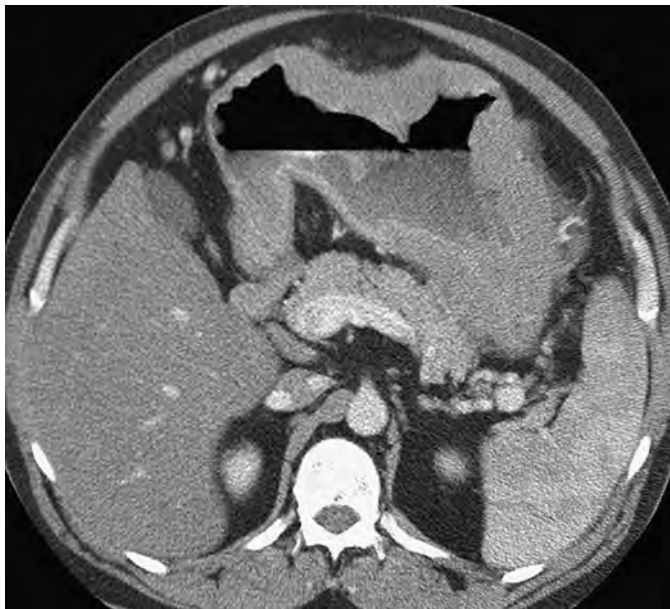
Gastric lymphoma on CT. CT scan shows marked thickening of the gastric wall with homogeneous enhancement caused by the infiltrative form of gastric lymphoma. Small perigastric lymph nodes are present in the adjacent fat.
